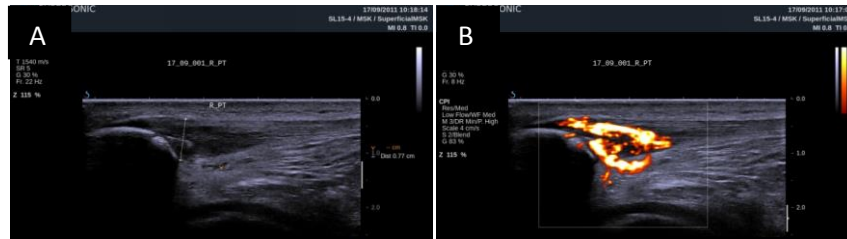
Ultrasound imaging of a patellar tendon with tendinopathy. (A) hypoechoic region and (B) increased vascularity.
